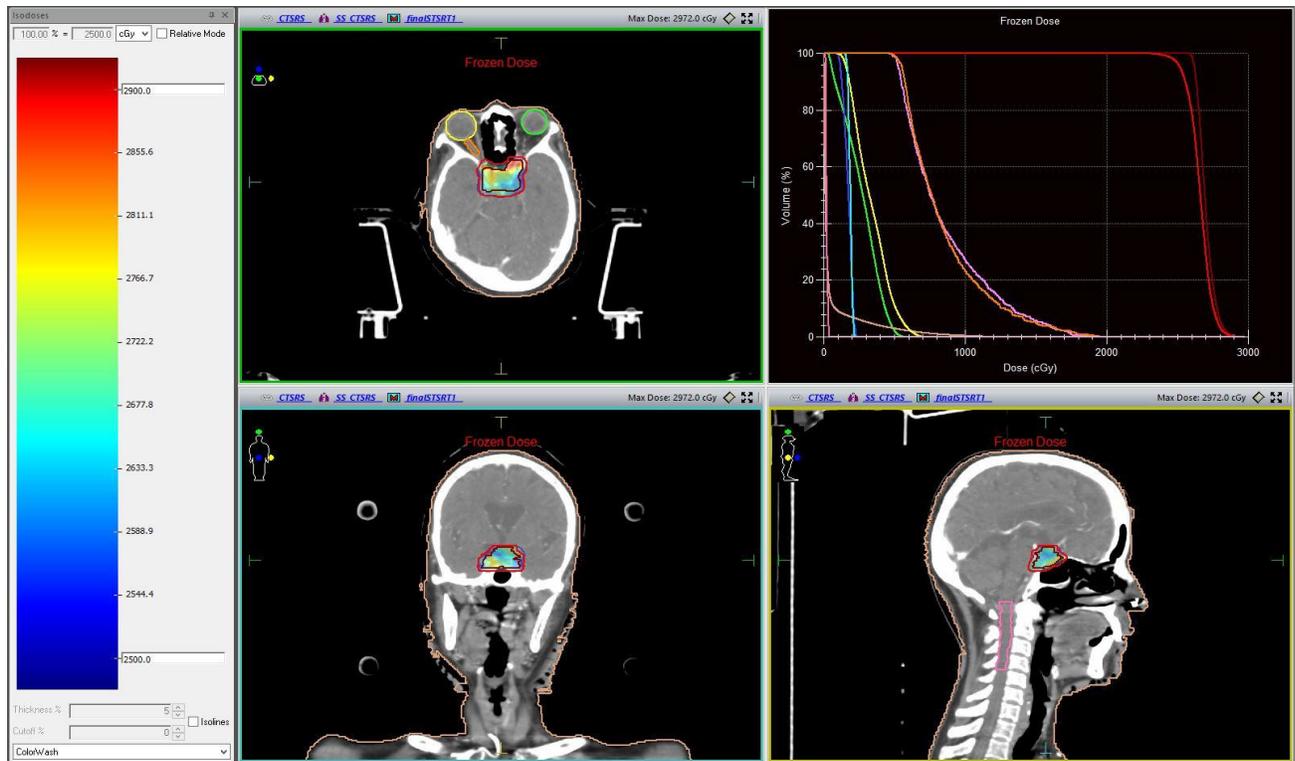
Axial, coronal and sagittal views of Treatment Planning CT Scan with iso-dose (ID) distribution (Blue – 50 % ID, Orange – 100 % ID and Brown - > 100 % ID) and Cumulative Dose Volume Distribution Graph.
